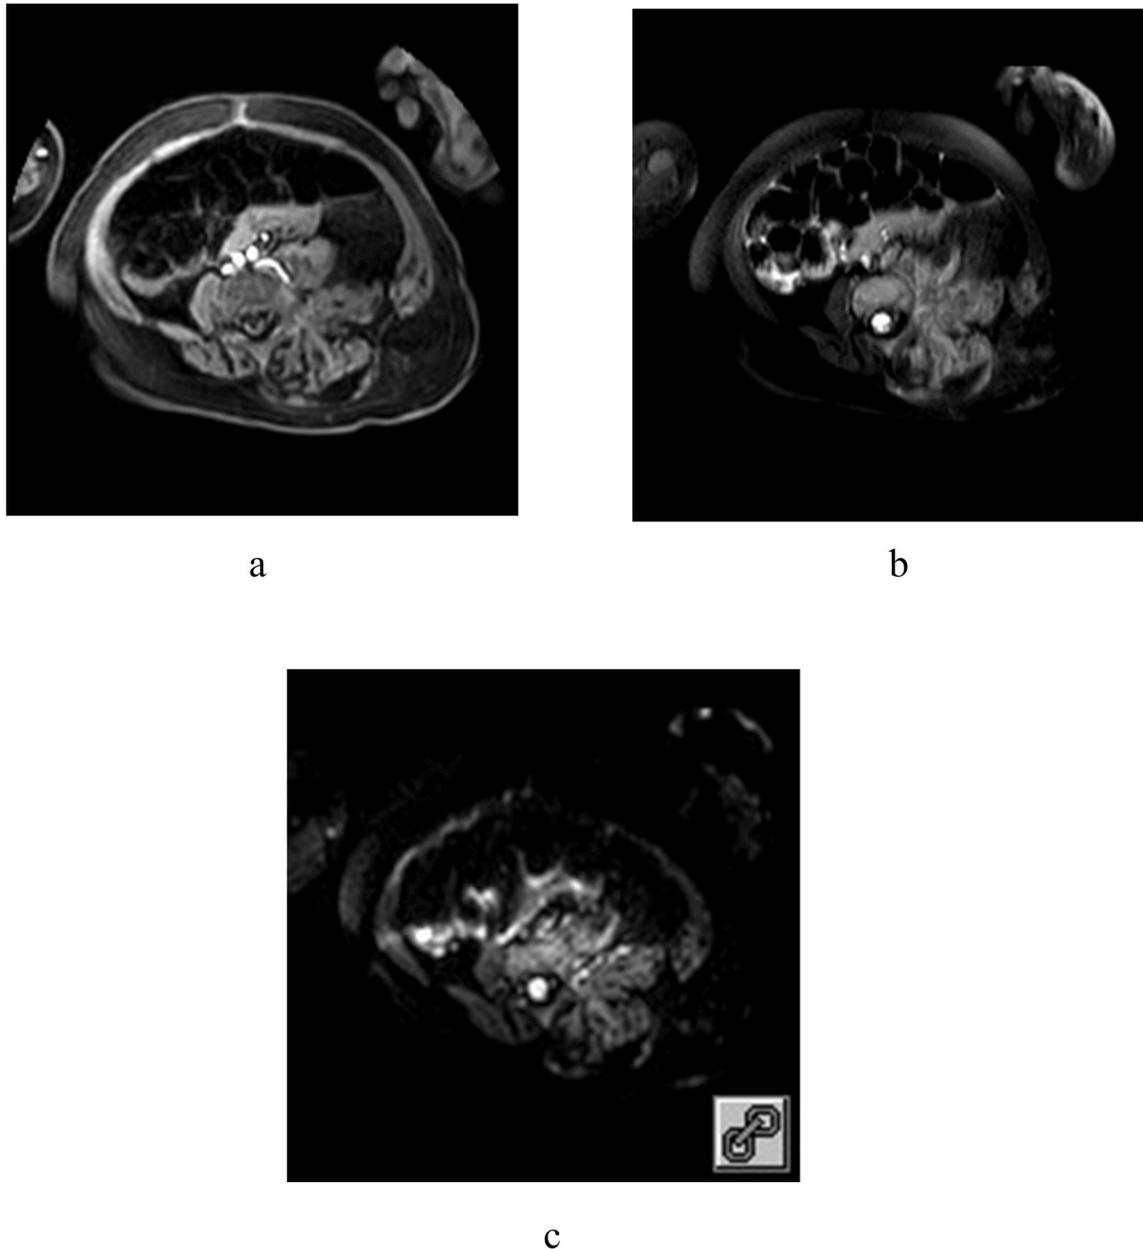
A male baby, 9 months, (A) T1-weighted image showed local soft tissue thickening and irregular mass-like mass, and surrounding muscle tissue was involved; (B) T2-weighted image showed high and low mixed signals; (C) DWI showed no obvious diffusion limitation.
